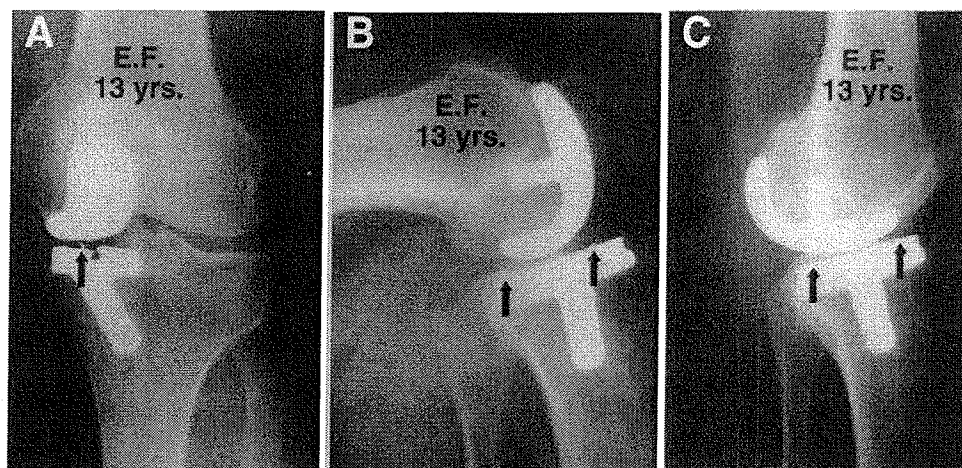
Thirteen-year follow-up of cementless LCS second generation (shorter tibial stem) medial UKA. (A) AP radiographs show maintenance of corrected position and preservation of lateral joint space. (B) Lateral flexion and extension views show meniscal bearing movement posterior in flexion and (C) anterior in extension. Arrows point to anterior and posterior metallic marker wires in polyethylene bearing.
